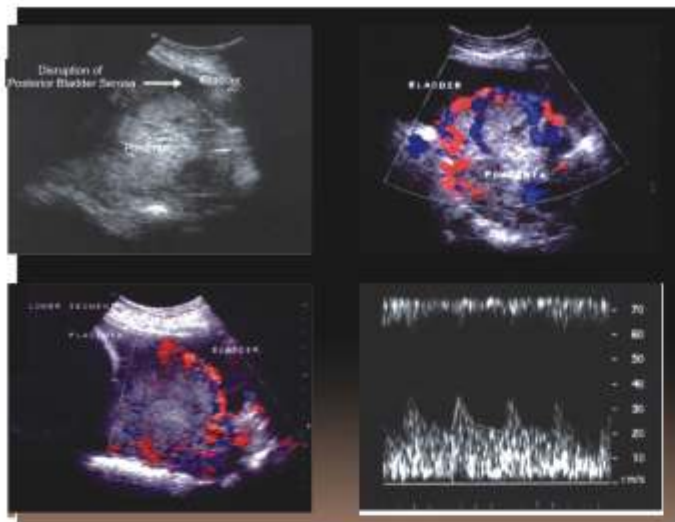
Grey Scale Imaging and Colour Doppler showing MAP
